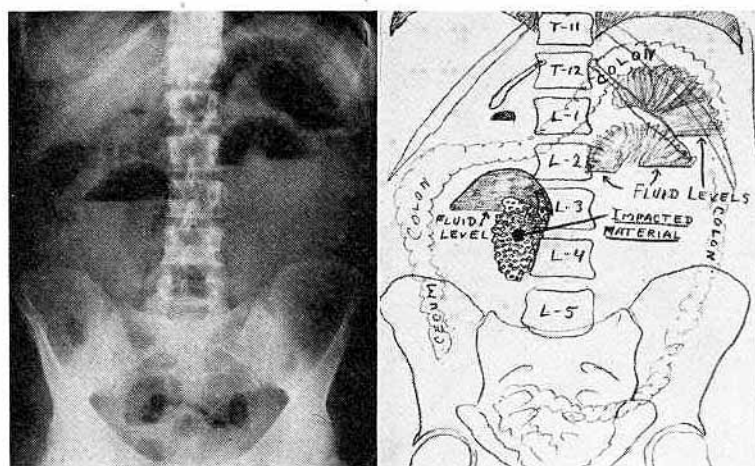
Case I. Ventral projection with patient sitting. Because the beam of x-rays was horizontal, fluid levels are visualized in the distended loops of obstructed small intestine. The actual point of obstruction is visualized in these films where the mass of undigested material is lodged, in the caudal end of a gas-distended loop of ileum, at the right border of the shadows of lumbar vertebrae L-3 and L-4. Such a film as this one immediately placed the obstruction in the ileum and not in any part of the colon. Had it not been for the availability of the Miller-Abbott tube, this patient would have needed immediate operation.
